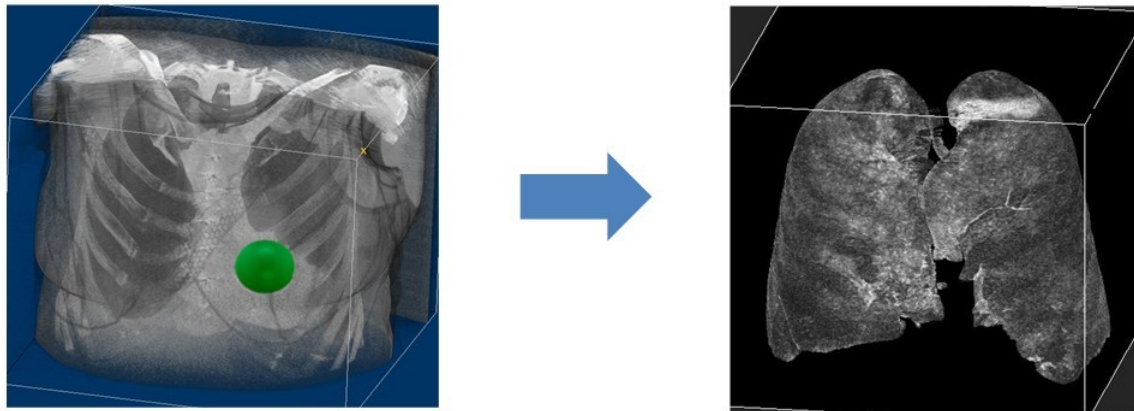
Left: 3D array of all CT images of a representative CT scan, segmented by 3D balls of different sizes shown as green on the picture. Right: Lung parenchyma segmentation viewed in 3D.
